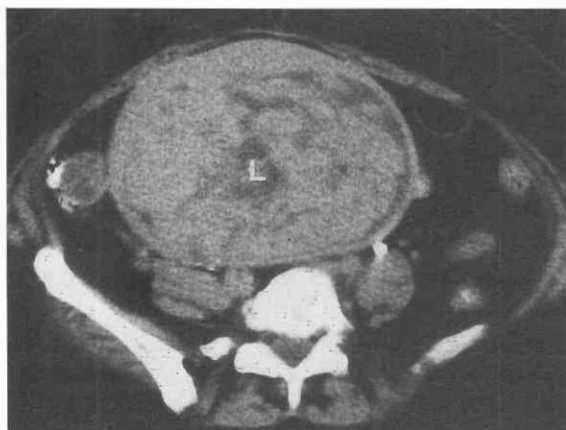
Large uterine leiomyoma. CT scan at the iliac crest shows a typical heterogeneous enhancement pattern of a giant leiomyoma (L) of the uterus.
